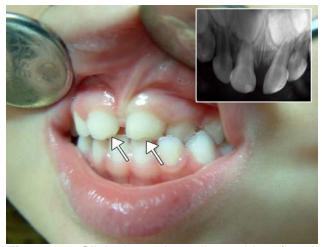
Clinical and radiographic (small picture) appearance of the traumatized teeth three months after trauma. Arrows indicate temporary restorations for the sealing of small enamel fractures.
